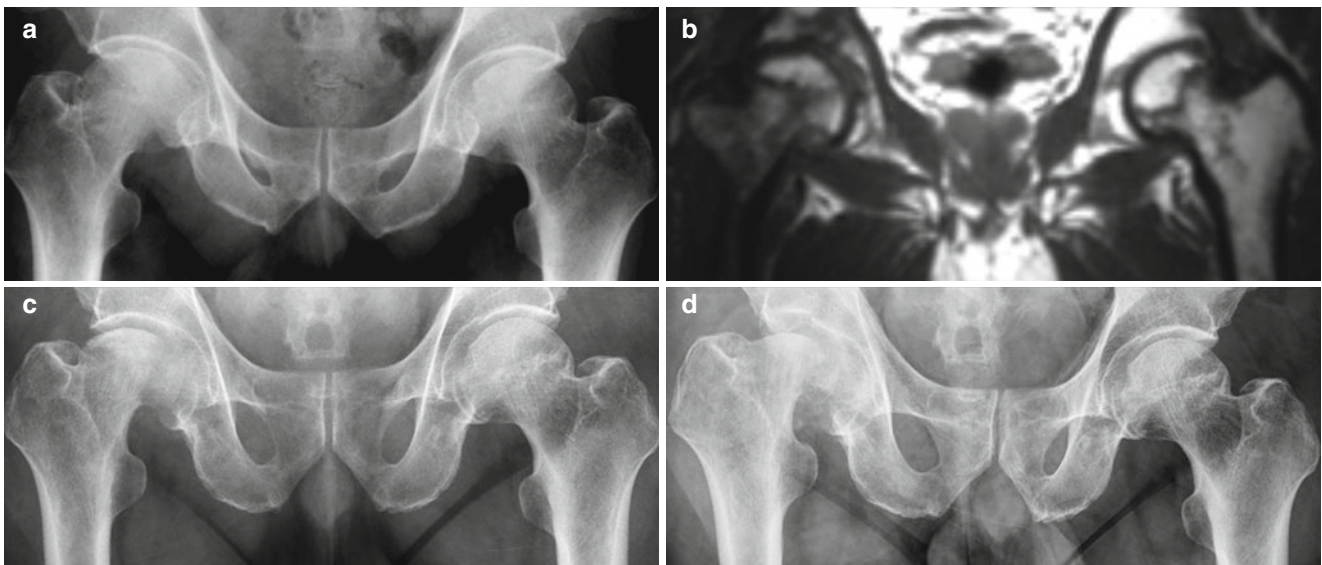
Rapidly destructive hip disease in a 63-year-old male patient. (a) Plain radiograph of the hip shows ON of both femoral heads. Contours of femoral heads are relatively preserved. (b) T1-weighted coronal image shows ON of both femoral heads. (c) Two months later from (a), the right
